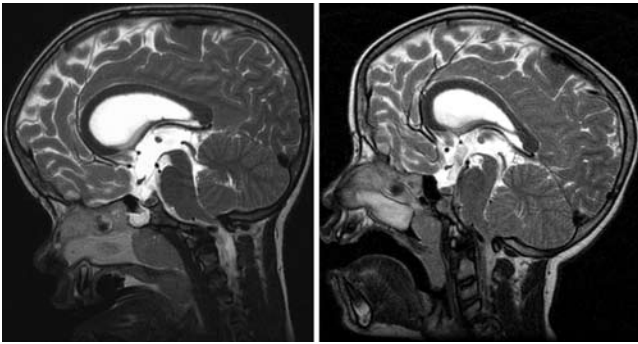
Preoperative (*left*) and postoperative (*right*) sagittal T2-weighted MR images obtained in an 8-year-old patient with severe headache who underwent an ETV, showing a flow void in the third ventricle and a reduction in size of the third ventricle.
